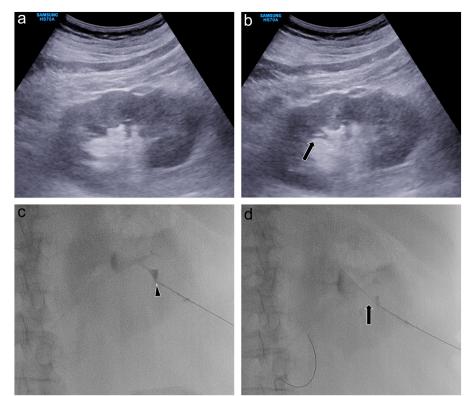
a-d. A 64-year-old man with catheter dislodgement 4 days after PCN catheter insertion. Ultrasonography image (a) shows nondilated renal collecting system without calyceal dilatation. Panel (b) shows a 21 G Chiba needle introduced through the center of inferior renal pyramid (*arrow*). On radiograph (c), a small amount of diluted contrast was gently injected via the needle (*arrowhead*) to opacify the renal collecting system. Panel (d) shows a 0.018-inch guidewire (*arrow*) inserted through the Chiba needle into the renal collecting system. Finally, an 8.5 F drainage catheter was successfully inserted (not shown).
